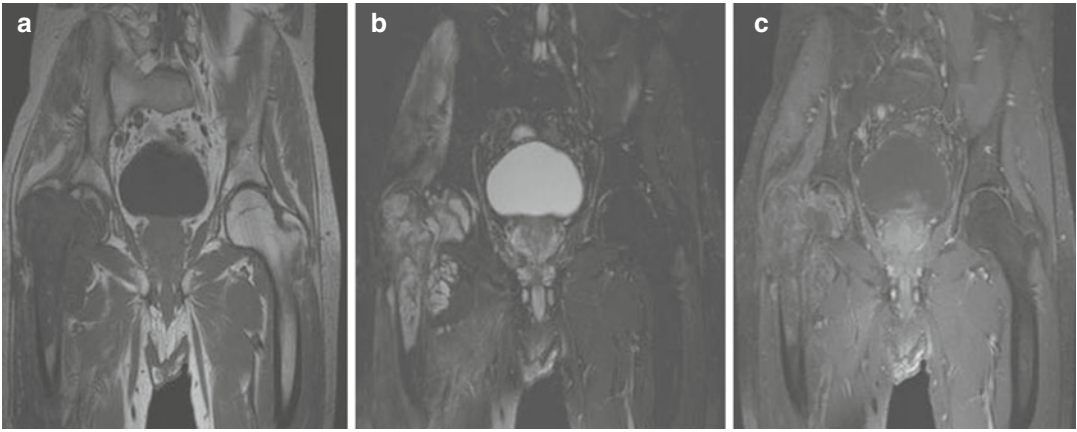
Chondrosarcoma located in the right femur. Coronal images with T1-weighted (a), fat saturated (FS) T2-weighted (b), and contrast enhanced FS T1-weighted
